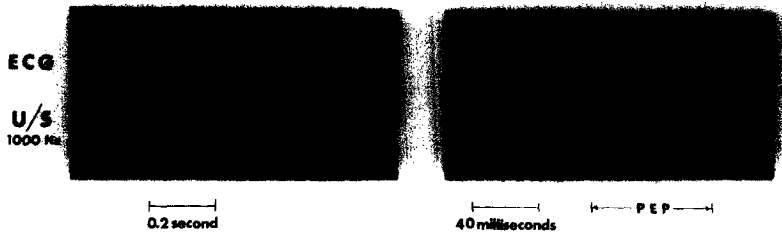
A 1,000 Hz ultrasound record from same subject as in Fig. 5A and 5B but 8 minutes later. Ao is now very prominent. There has been no change in the pre-ejection period.
